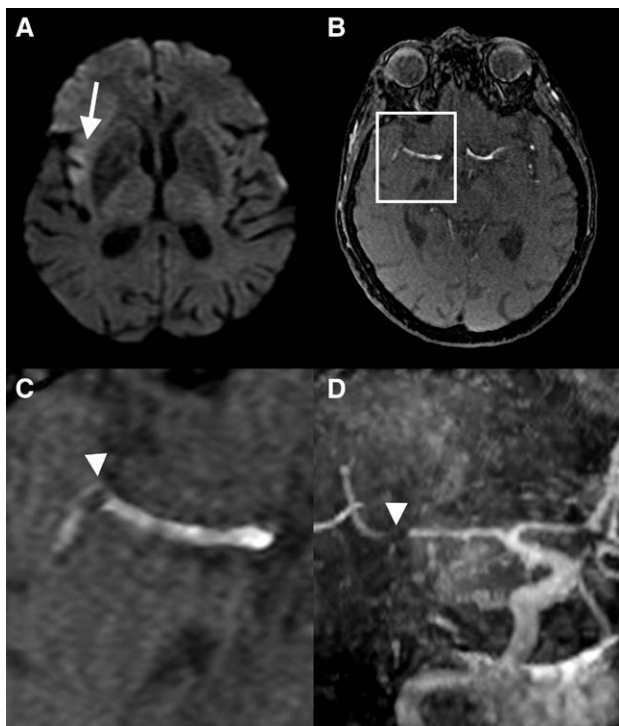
A, Diffusion-weighted MRI showing ischemia (faint hypersignal; arrow) in the territory of the right middle cerebral artery. B to D, Magnetic resonance angiography showing partial occlusion of the right middle cerebral artery (arrowhead) on 3-dimensional time-of-flight sequences. C, Close-up of the boxed area in B.
